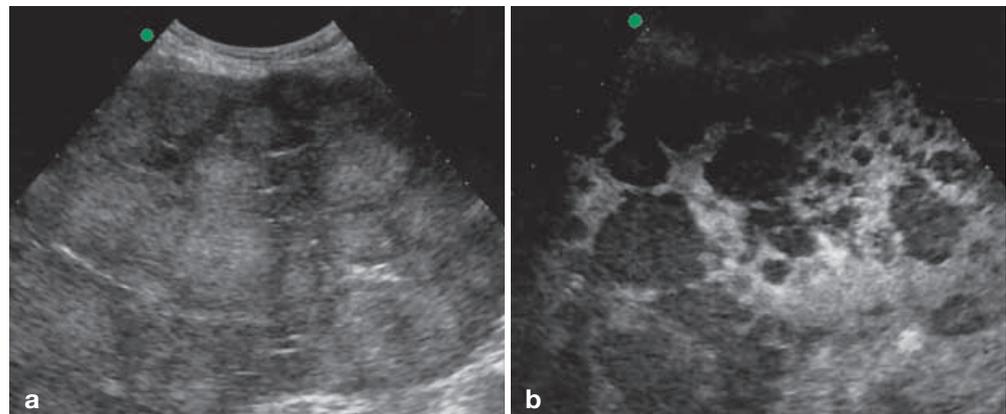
C-cube imaging of the liver. a Ultrasound in fundamental mode shows multiple focal lesions that are hyperechoic with respect to liver parenchyma. b In the C-cube image obtained in the late phase following contrast injection, destruction of microbubbles in hepatic sinusoids results in strong enhancement of liver parenchyma, with focal lesions remaining unenhanced. Numerous additional small nodules become visible
